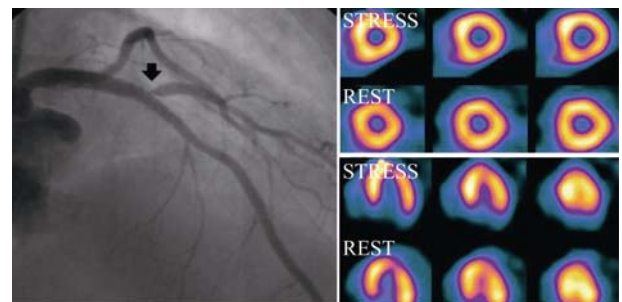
Mismatch between angiographic severity and functional significance. Despite the tight angiographic stenosis, no perfusion defect was found on myocardial SPECT scan (right panel). FFR at this jailed diagonal branch was 0.81.
